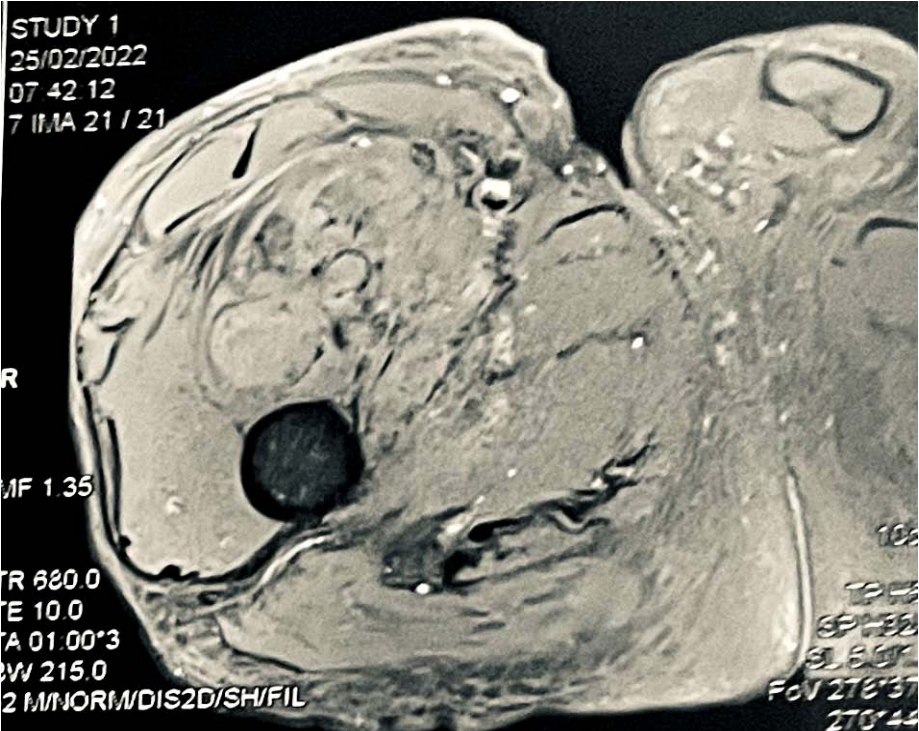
Axial cut of a thigh MRI showing partial response to chemo-radiation
